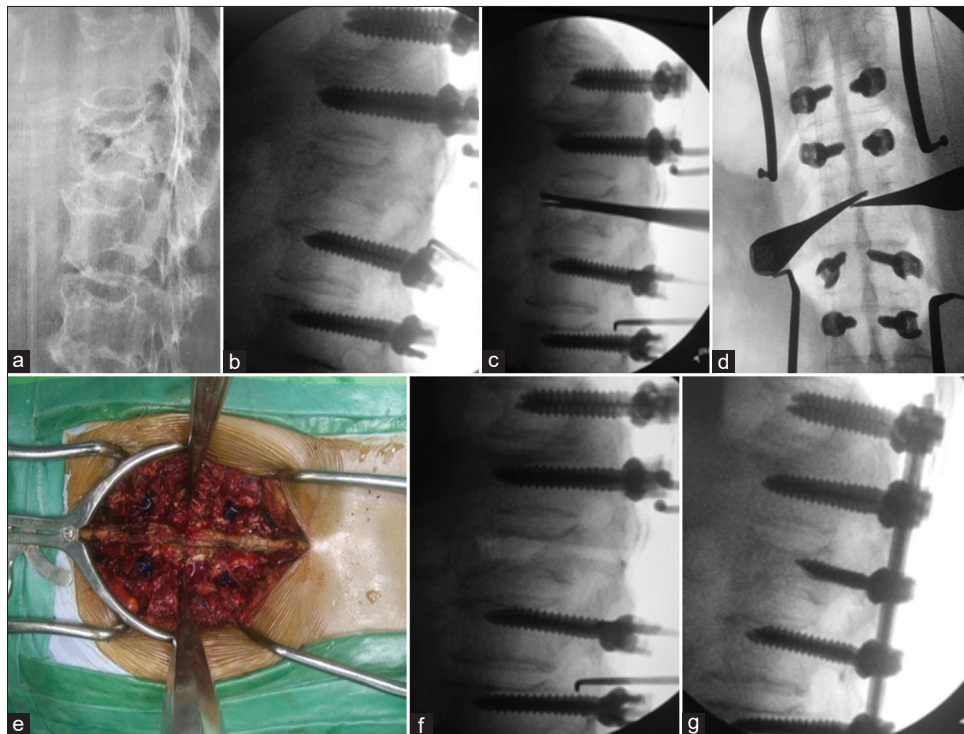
(a) Preoperative radiograph shows osteoporotic fracture with kummel's lesion and local kyphosis; (b) intra-operative radiographic image showing fracture site mobility and correction of local kyphosis after prone position on operative table; (c-e) serial expansion and dilatation of both pedicles of fracture vertebrae and debridement and preparation of Kummel's lesion with blunt tip curettes; (f) fracture vertebrae after debridement and preparation; (g) after uniform cancellous bone grafting and instrumentation of previously debrided and prepared fracture vertebrae
